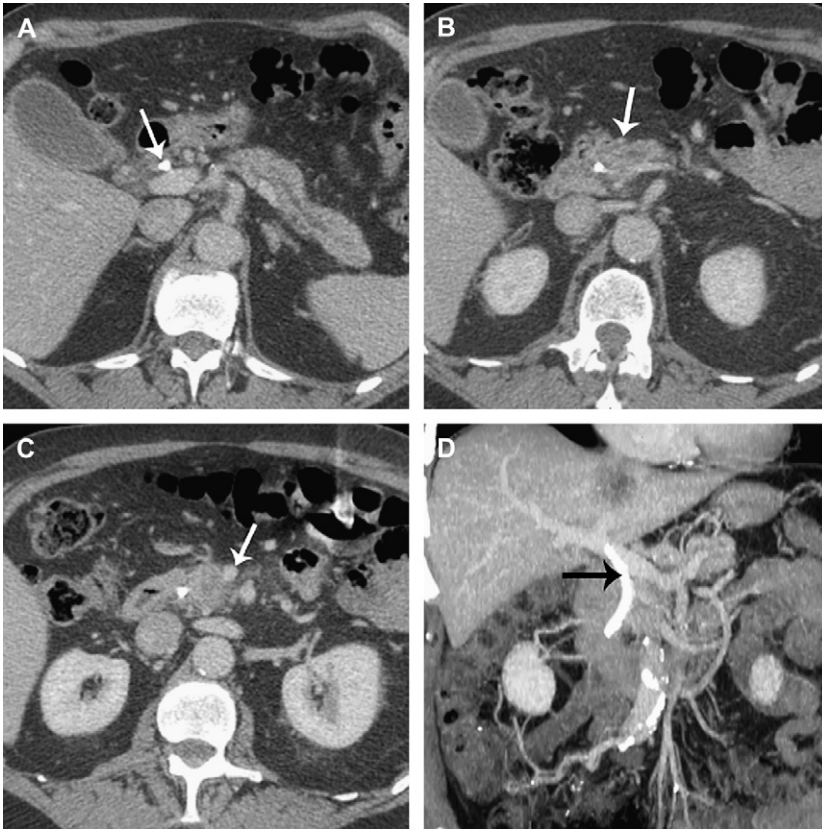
“Unresectable” pancreatic head carcinoma. (A) Axial CT section shows a dilated pancreatic duct and infiltration of the planes surrounding the celiac artery. A plastic biliary stent (*arrow*) is noted. (B) The hypodense tumor (*arrow*) obliterates the splenic-portal confluence. (C) The tumor touches the superior mesenteric artery and surrounds approximately half the circumference of the superior mesenteric vein. (D) Coronal reformation of the CT scan shows the biliary stent (*arrow*) and the patent superior mesenteric vein and portal vein, but the splenic vein is not seen.
